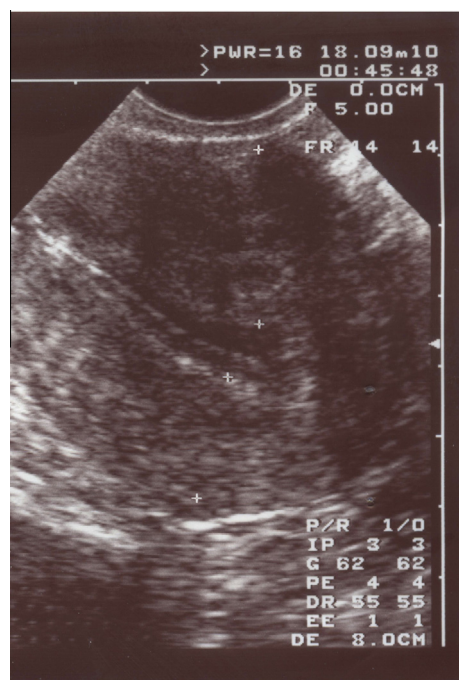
Ultrasound showing adenomyosis in one of the patients prior to surgery, showing adenomyotic tissues in the anterior and posterior walls of the uterus (interval space between '+' signs).
